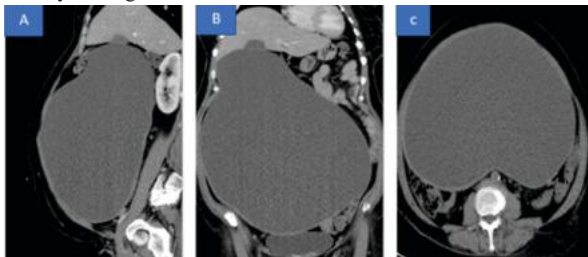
CT Scan Depicting the Ovarian Tumor in the Sagittal a), Coronal b) and Axial Images c).
